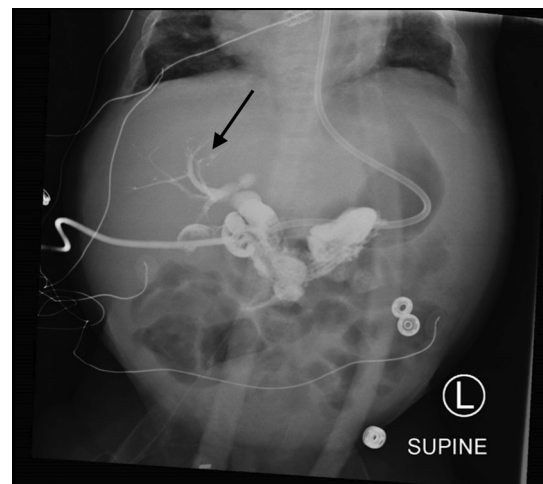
Gastrografin injection was attempted due to continued rise in bilirubin. Post-injection radiograph showed contrast filling the dilated intra- and extrahepatic biliary system (arrow).
